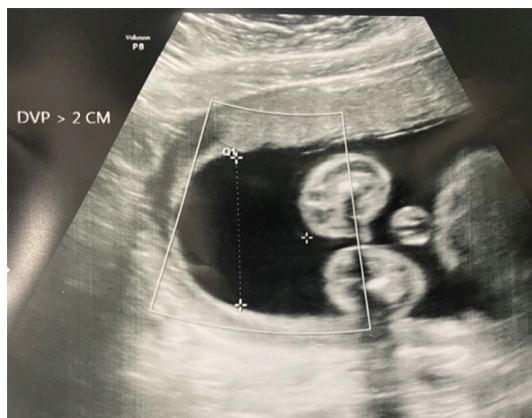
Transverse view of maximum vertical pocket without fetal part or umbilical cord as detected by color Doppler. DVP indicates deepest vertical pocket.
